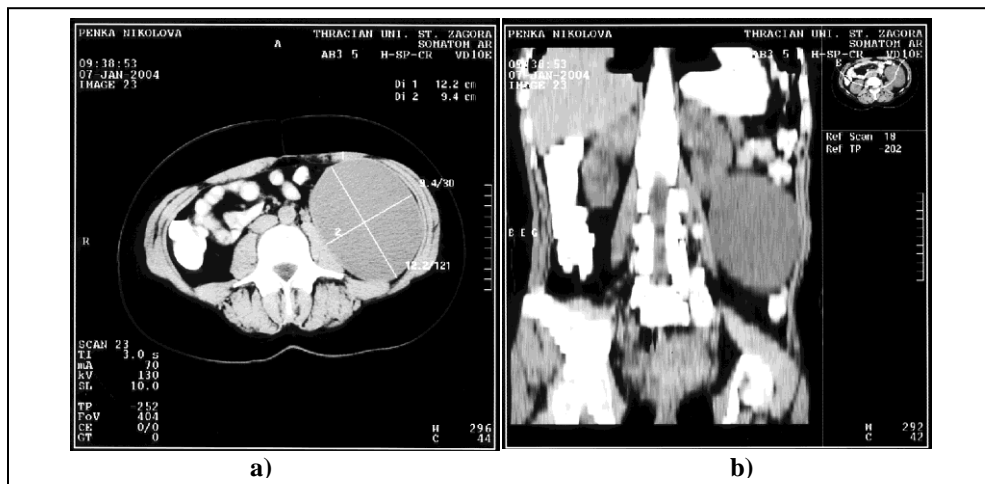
Abdominal CT showing a 12, 2 cm x 9, 4 cm homogenous, hypoattenuating, well-defined cystic mass, located latero-caudal pararenal in the left retroperitoneal space. a) axial and b) coronal reconstruction.
